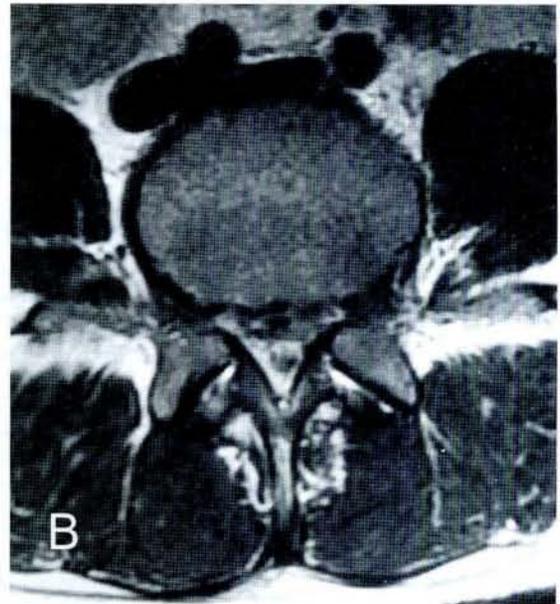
1B: T2-weighted sagittal and axial images (A and B) show a sequestered fragment that was migrated posteriorly and superiorly to the dural sac at L4-L5 level.
